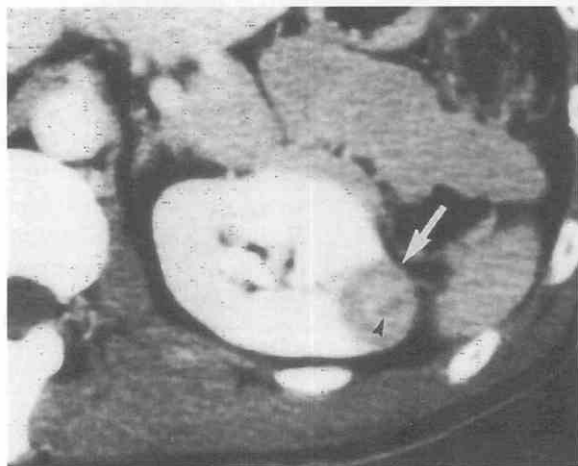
Left renal oncocytoma (arrow) with eccentric scar (arrowhead). Distinction from a small renal cell carcinoma is not possible on CT.
